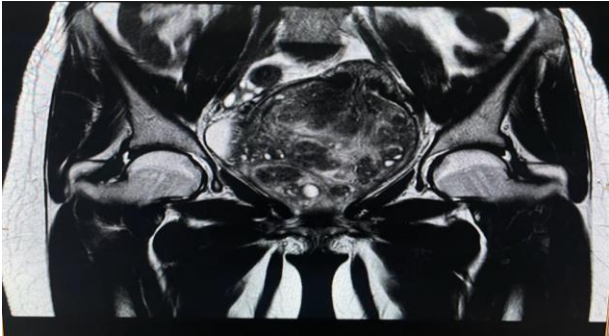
The coronal section of the MRI film shows a large mass that is heterogeneous with hyperintense to isointense areas in between. The mass is distending the vagina.
